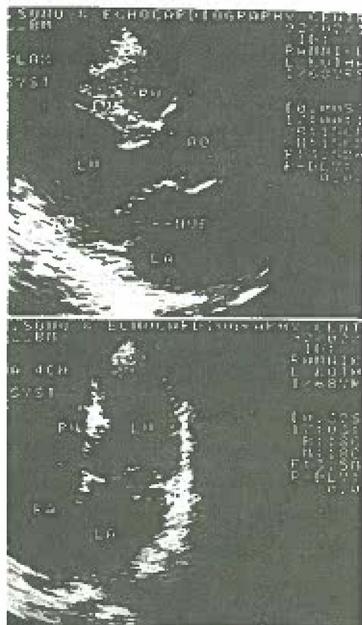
36: 2D Echo in left parasternal long axis view (upper one) & apical 4 chamber view (lower one) showing mitral valve prolapse
